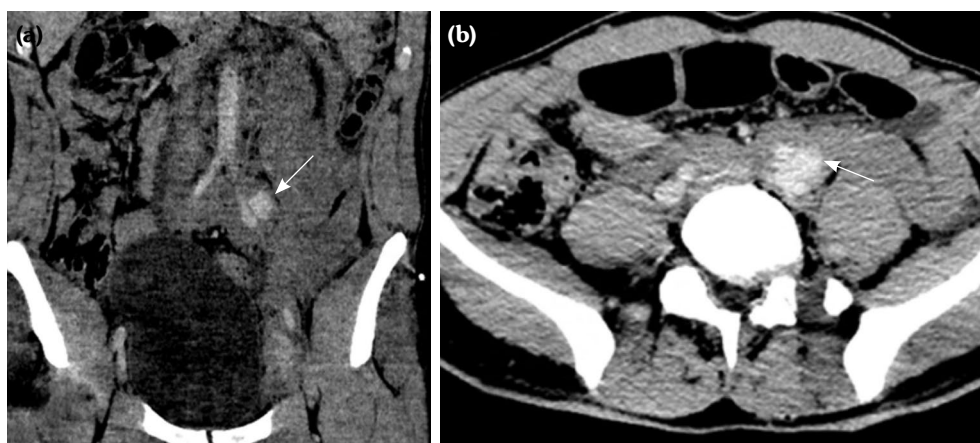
Abdominal CT angiography images. (a) Coronal, (b) Axial, pseudoaneurysm (arrows).
